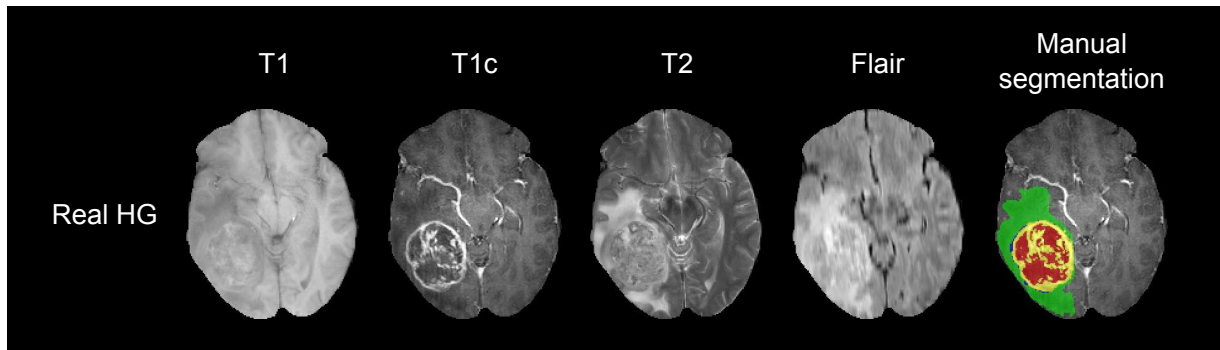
Example of an axial slice of different MRI sequences from a patient of the BRATS 2013 dataset, showing a GBM tumour and the manual segmentation provided by expert radiologist. From left to right: T_1 , T_{1c} , T_2 , FLAIR, and manual segmentation overlaid on the T_{1c} image.
